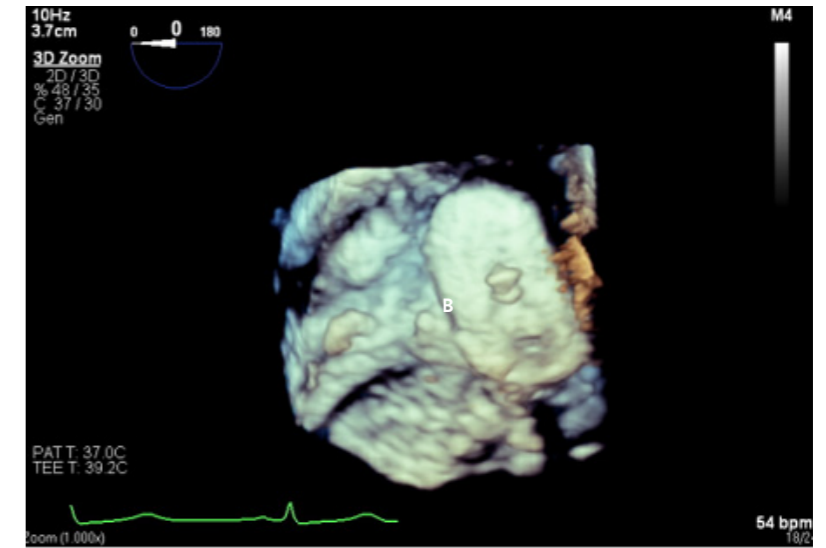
Post-procedure 3D Transesophageal echocardiogram left atrial view showing the AVP III plug with normally functioning mitral valve
